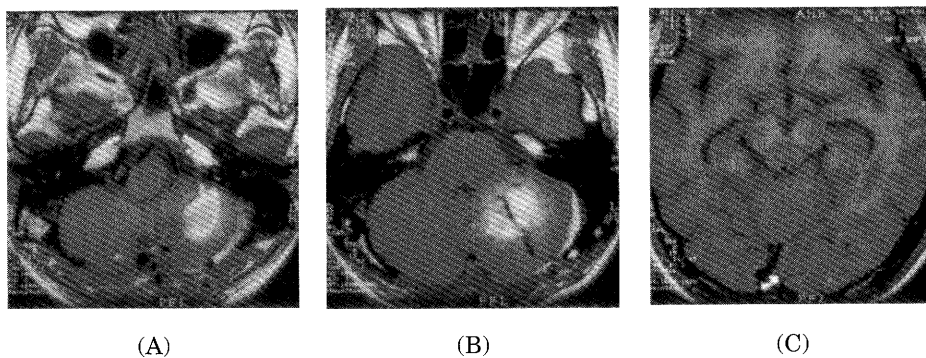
MRI on the twenty third day showed a left cerebellar hematoma and flow void that indicated venous angioma. Tightness in the posterior fossa was improved compared to the CT on admission.
